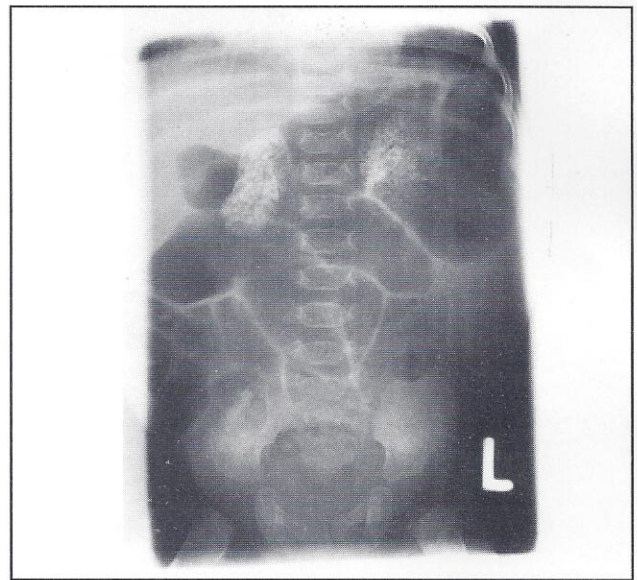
Plain radiograph of the abdomen showing bilateral suprarenal enlargement and calcification
